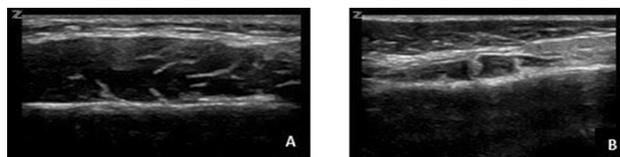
Ultrasound images m. masseter. A. healthy boy (12,0 years), EG z-score 0.2, thickness z-score 0.5; B. boy with MD1 (12,75 years), EG z-score 3.9, thickness z-score -2.3
